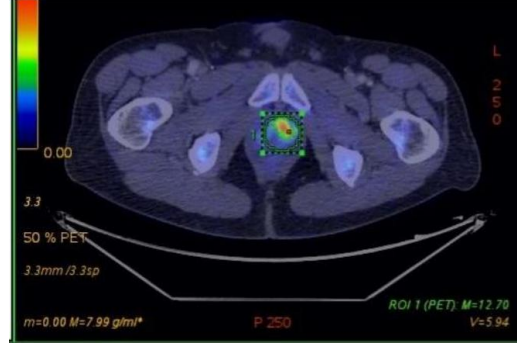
$^{18}\text{F}$  choline PET-CT in prostate cancer
